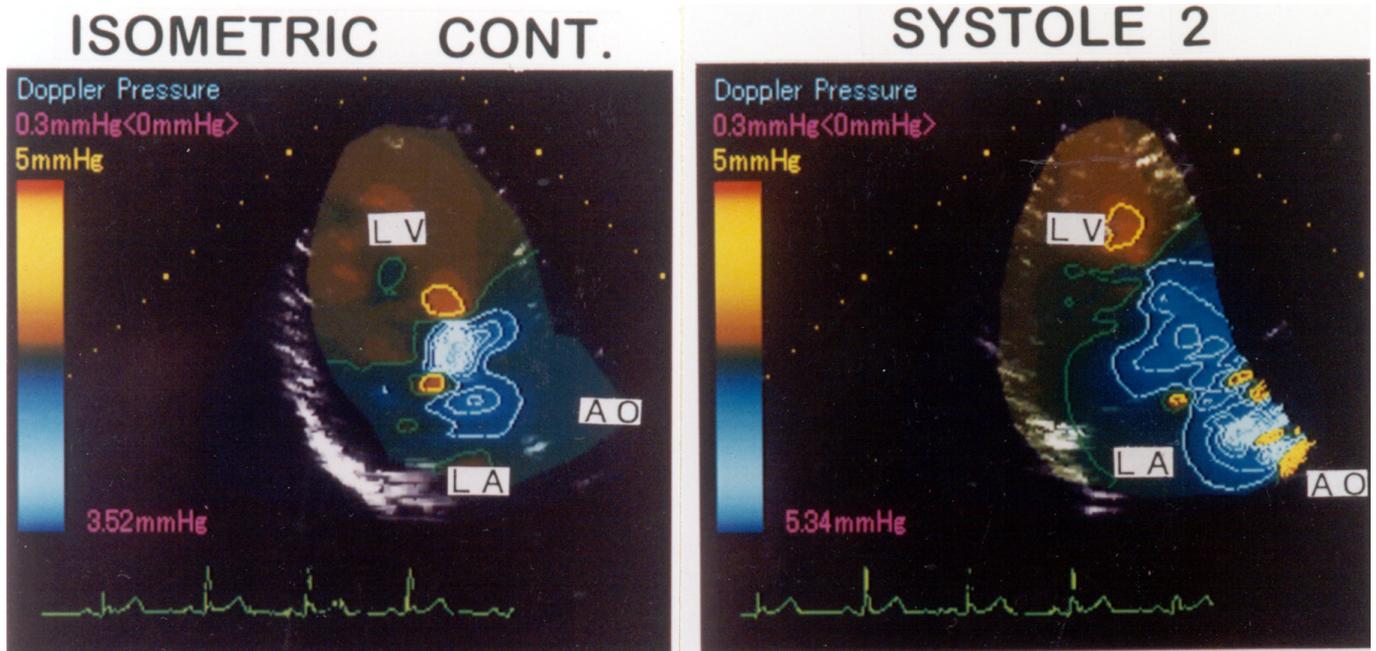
2-dimensional Doppler pressure distributions at two cardiac phases in systole obtained from a normal subject. The pressure value is represented by equipressure lines. Intervals between two adjacent pressure lines are 0.3-mm Hg step. The maximum pressure difference in each cardiac phase is shown at the left lower corner by the number. The red-colored area shows relatively higher pressure area, and the blue-colored area shows the lower pressure area. The green line indicates the standard level (0 level).
